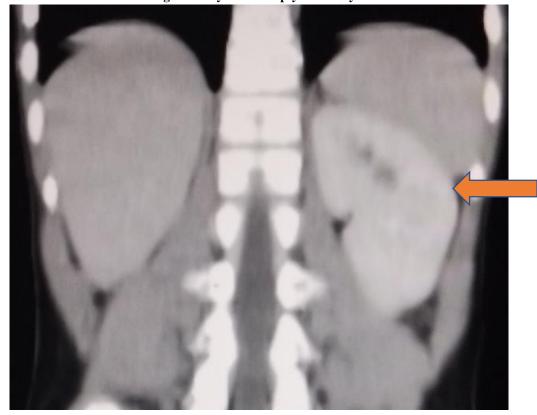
is a coronal reformat contrast enhanced computed tomography image showing the left kidney with prompt uptake of contrast (orange arrow). The right kidney is not visualized.
